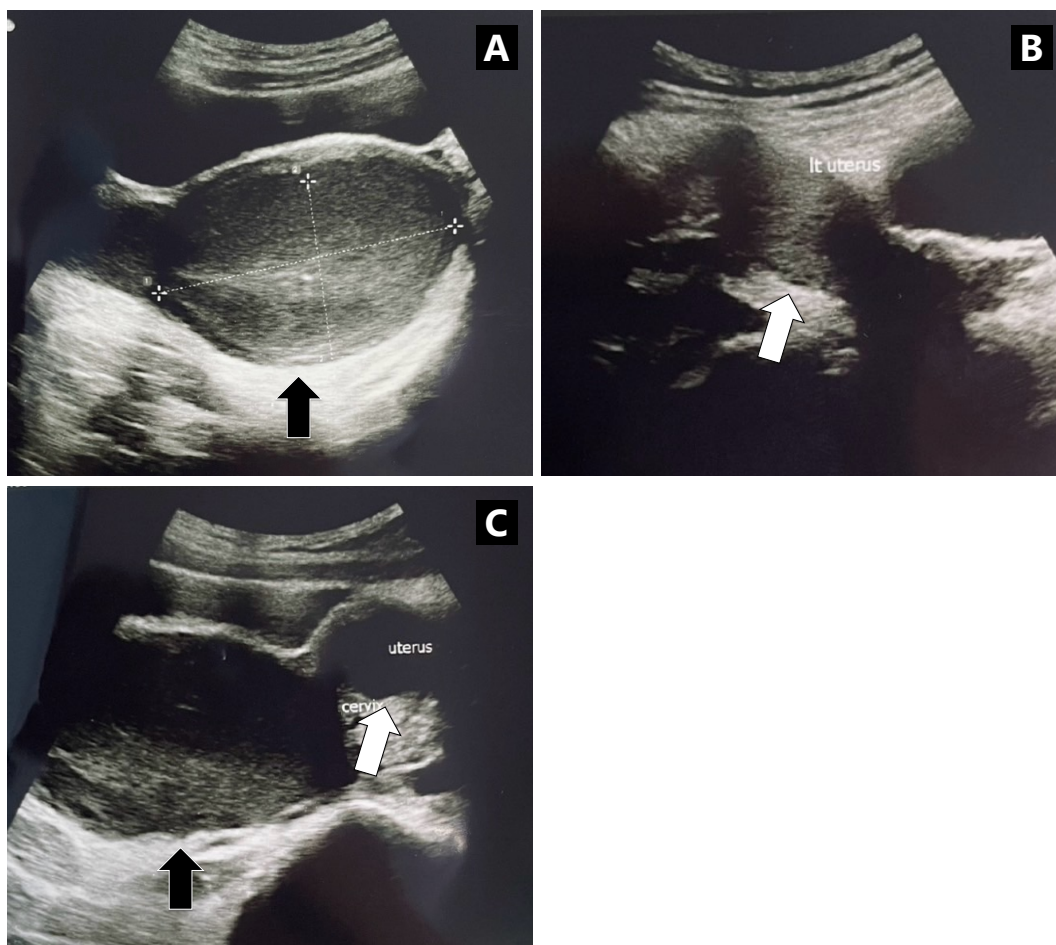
Transabdominal ultrasonography shows a well-defined hypoechoic cystic mass in the mid-pelvic cavity (A and C, black arrow) and the left uterine horn in the left pelvic cavity (B and C, white arrow).
